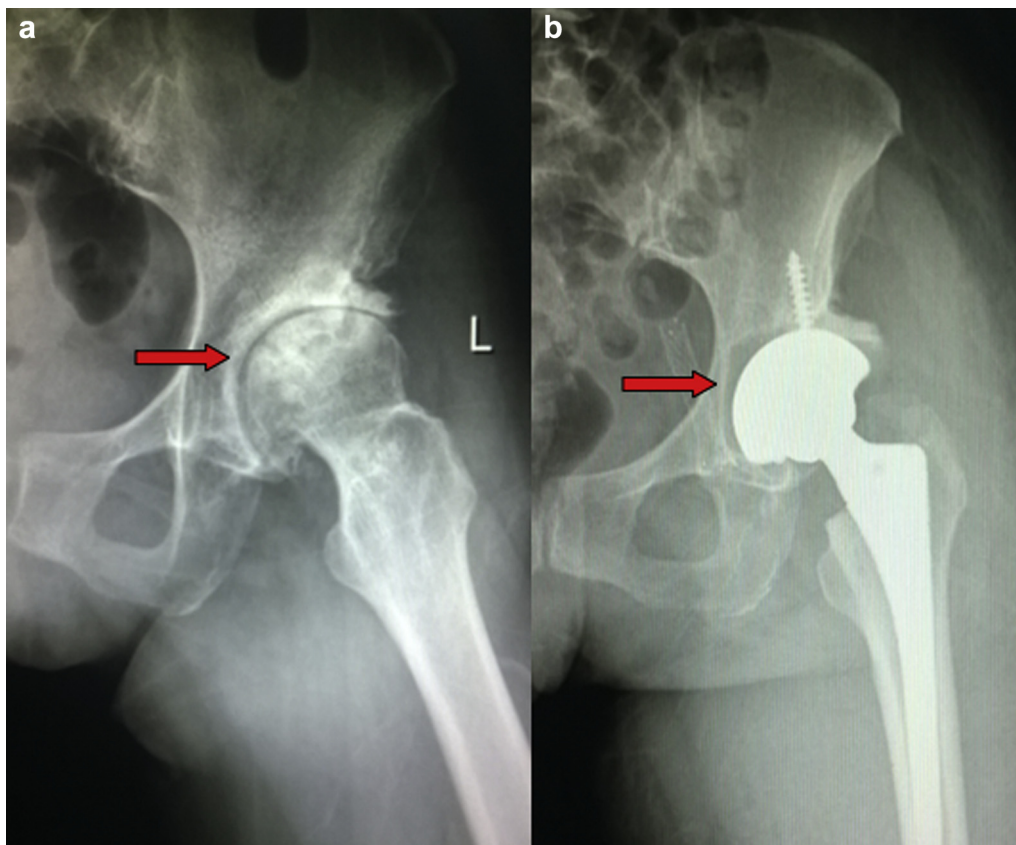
Posterior-anterior view of radiograph before (a) and after (b) operation (red arrow indicates the position of osteophytes on the anterior edge of acetabulum).
